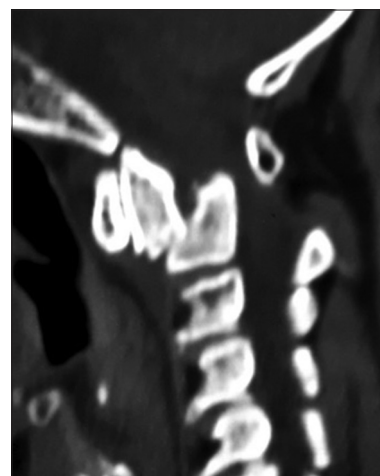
Computed tomography – Sagittal cuts showing complete anterior translation of dens with irreducible atlantoaxial dislocation
